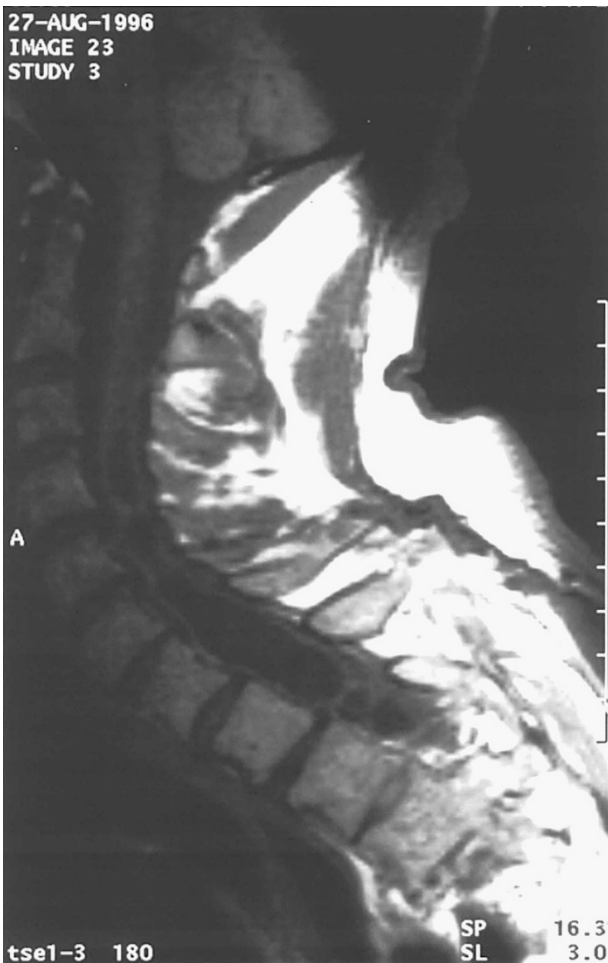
MRI of the cervical and upper thoracic spine. There is a fracture of T4 with an anterior dislocation of T3. A lobulated syrinx is seen from C3 to T3
